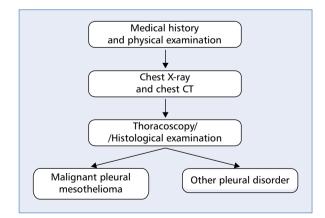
Principles of diagnostic procedures in malignant pleural mesothelioma. CT — computed tomography
